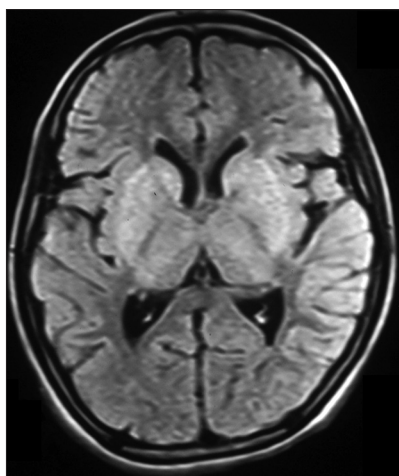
MRI brain T2-weighted section showing bilateral striatal changes in a child with KF rings and dementia suggestive of Wilson disease
